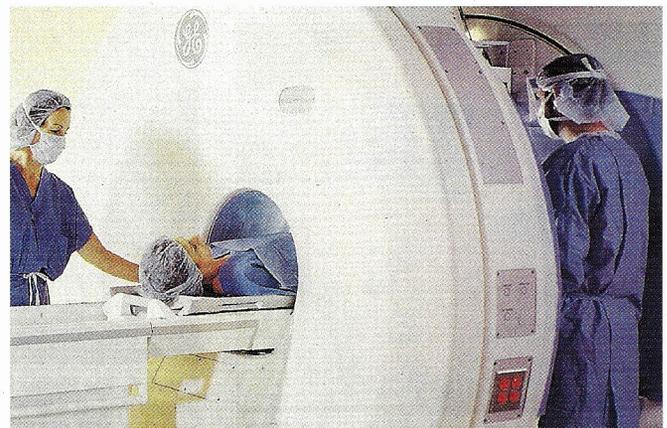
The surgical field is placed between the paired magnets to allow direct vision of the site and simultaneous display of MR images for navigation and monitoring of therapy.
